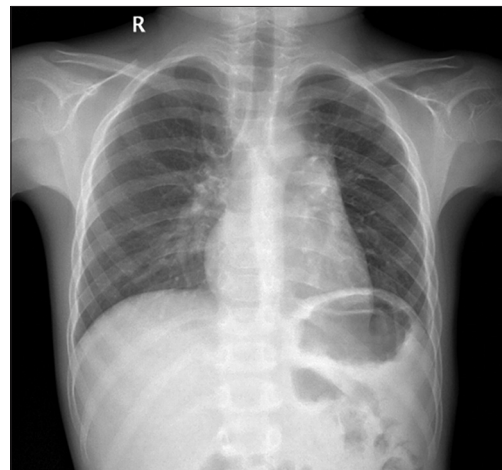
Chest X-ray on follow-up showing good aeration in the left lung
